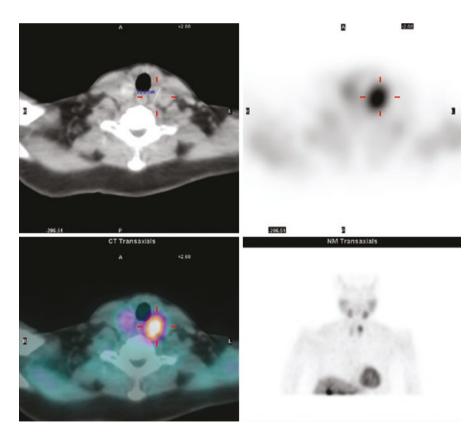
CT/MIBI image showing an enlarged parathyroid in left upper position
